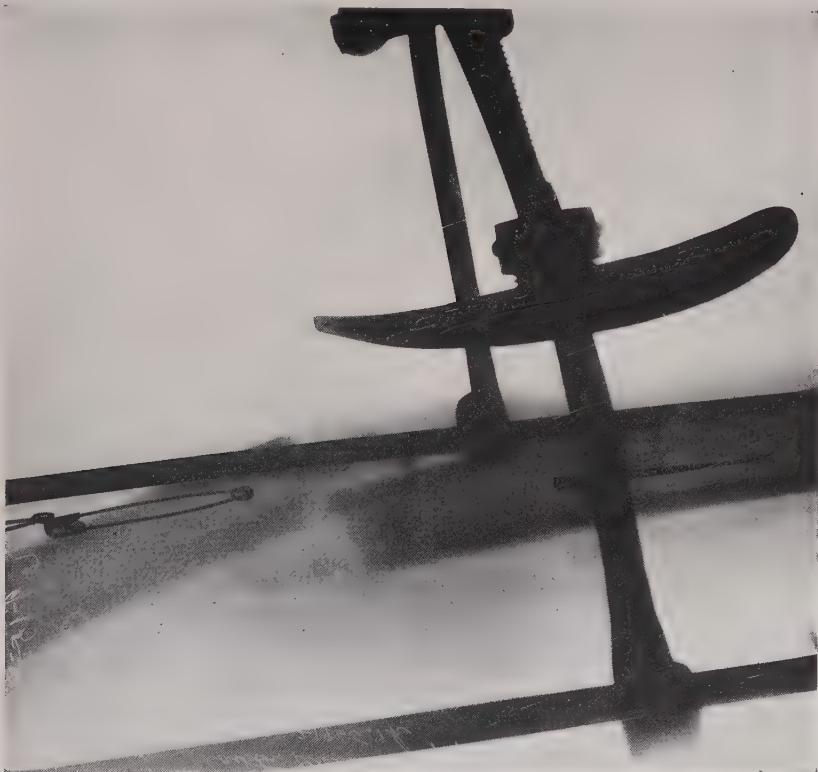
Roentgenogram showing pressure pad in position to correct displacement in the antero-posterior plane. In this case, over-correction of the original deformity has been obtained. (Fracture Service, M. G. H.)
